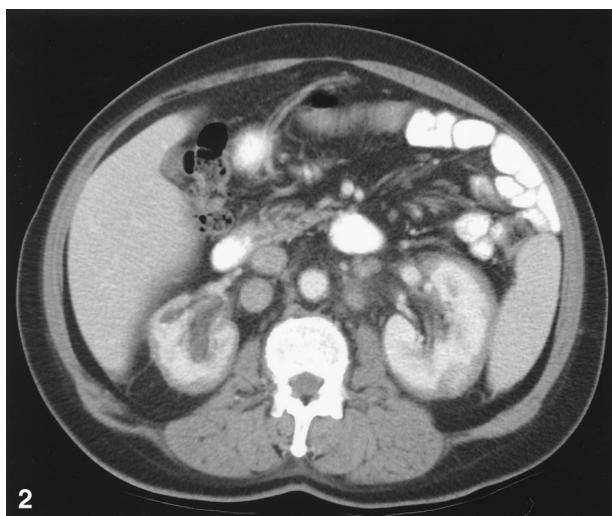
Case 1. Delayed contrast-enhanced CT shows an enhancing infiltrative soft tissue mass in the left renal hilum encasing and narrowing the contrast-containing renal pelvis and calyces.
